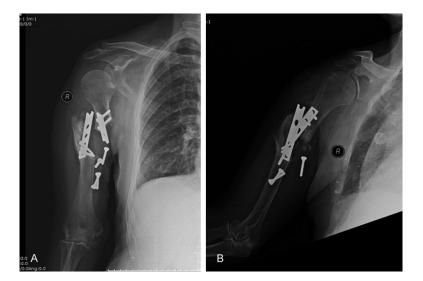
Preoperative anteroposterior (A) and lateral (B) radiographs showing humeral shaft atrophic nonunion and broken plate.
